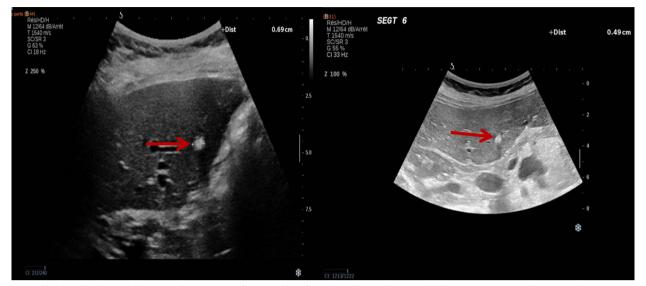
Abdominal ultrasound showing the presence of comet tail artifacts along the intrahepatic bile ducts, consistent with LPAC syndrome
